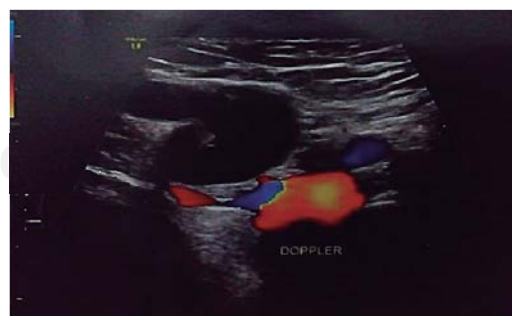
Ultrasound of inguinal region with cystic sac and color Doppler imaging.
